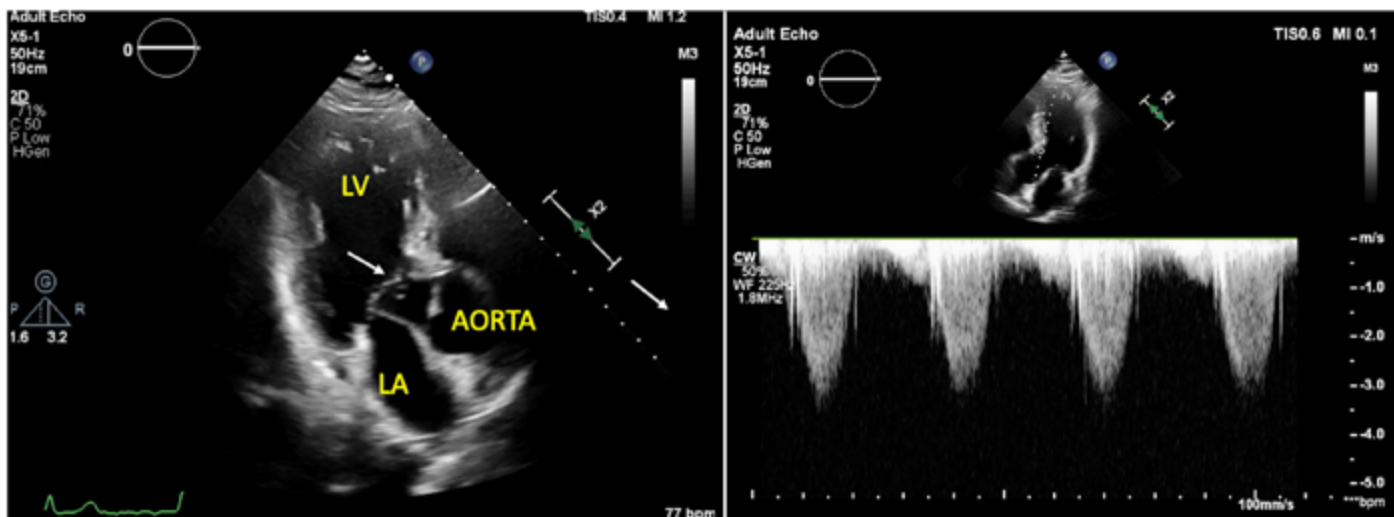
Mitral accessory tissue (white arrow) mimicking systolic anterior motion in transthoracic echocardiography apical 3-chamber view (A) and left ventricular outflow tract gradient with a maximum of 28 mmHg measured by continuous-wave Doppler (B) (LA, Left Atrium; LV, Left Ventricle).
